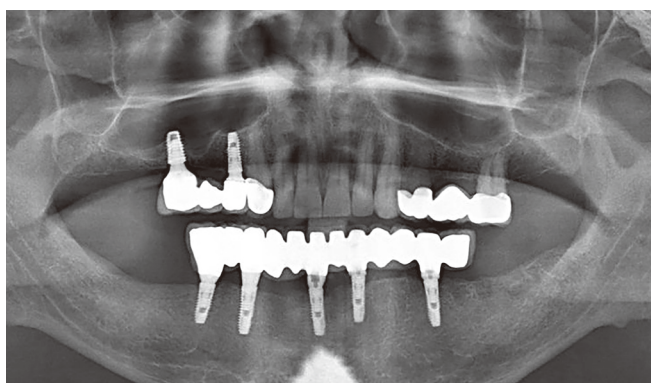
X-ray control after 1.5 years.
